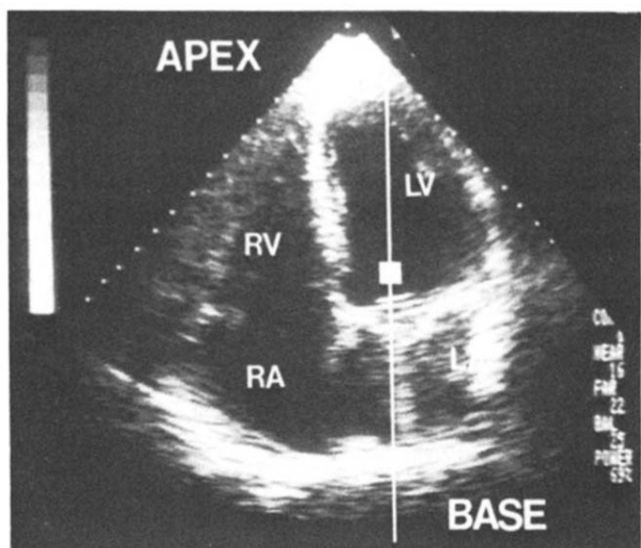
Two-dimensional echocardiographic apical four chamber view (top) and pulsed mode Doppler study (bottom) in a patient with a normal 31 mm St. Jude valve in the mitral position. The flow pattern resembles that of a normal native mitral valve. The peak velocity is only 1 m/s and the peak gradient is 4 mm Hg. MVR = mitral valve replacement; other abbreviations as in Figure 1.
